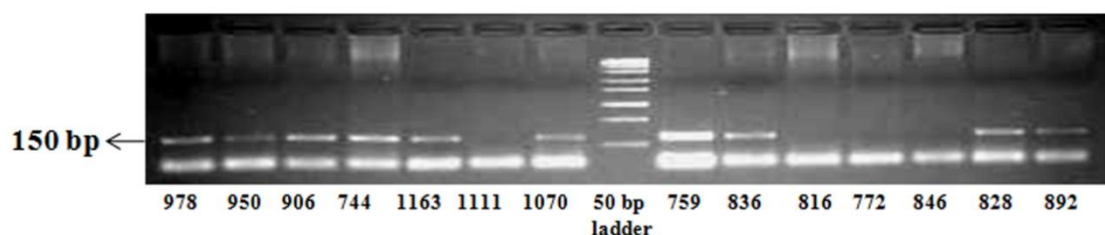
HPV positivity in cervical cancer biopsies by GP5⁺/6⁺ primers set. DNA from cervical cancer biopsies were PCR amplified using GP5⁺/6⁺ consensus primers and resolved on 2% agarose gel. Presence of 150 bp band confirms HPV positivity. The sample names begin with 'CT' followed by the lab code. M= 50 bp ladder.
